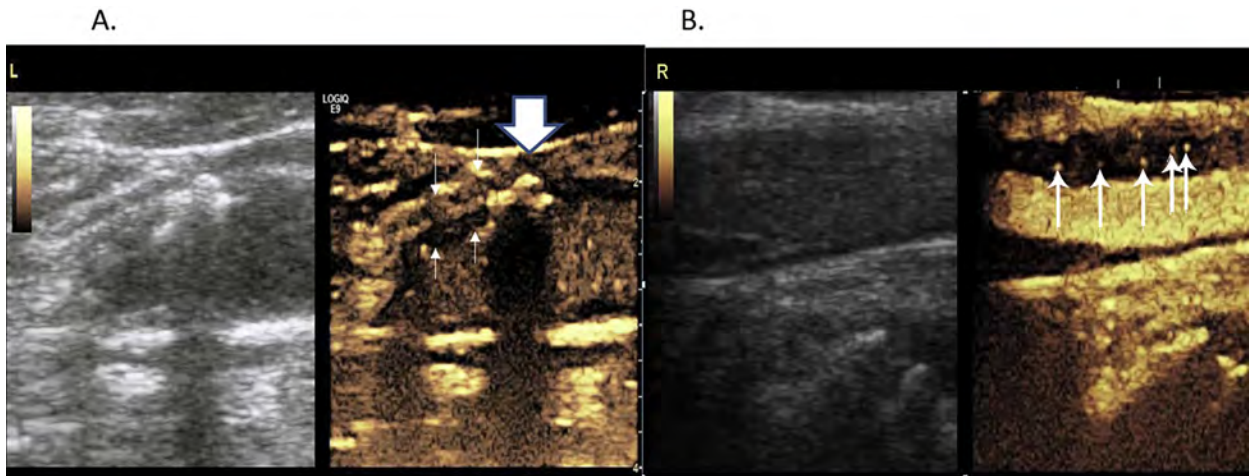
An example of carotid B-mode ultrasound images and contrast-enhanced low-MI harmonic images side by side in a patient with calcific carotid plaque (*large arrow*) (A) and minimal plaque neovascularization (*thin white arrows*). The second patient (B) has more extensive adventitial plaque neovascularization extending into the intima (*white arrows*). See [Video 12](#), available at www.onlinejase.com.
